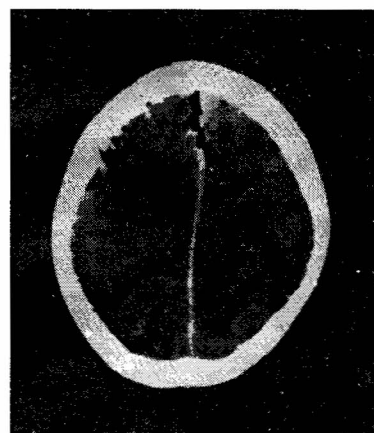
CT scan showing intracranial air in a patient with a dural fistula
